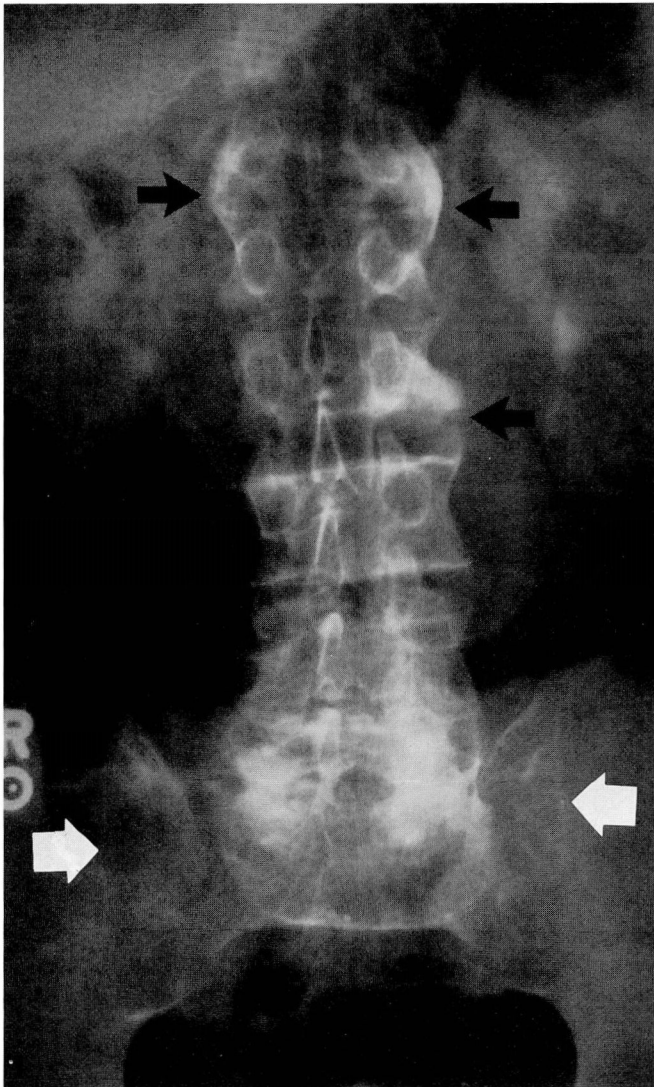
Anteroposterior radiograph of the pelvis and lumbar spine showing syndesmophytes (black arrows) and complete fusion of both sacroiliac joints (white arrows).
